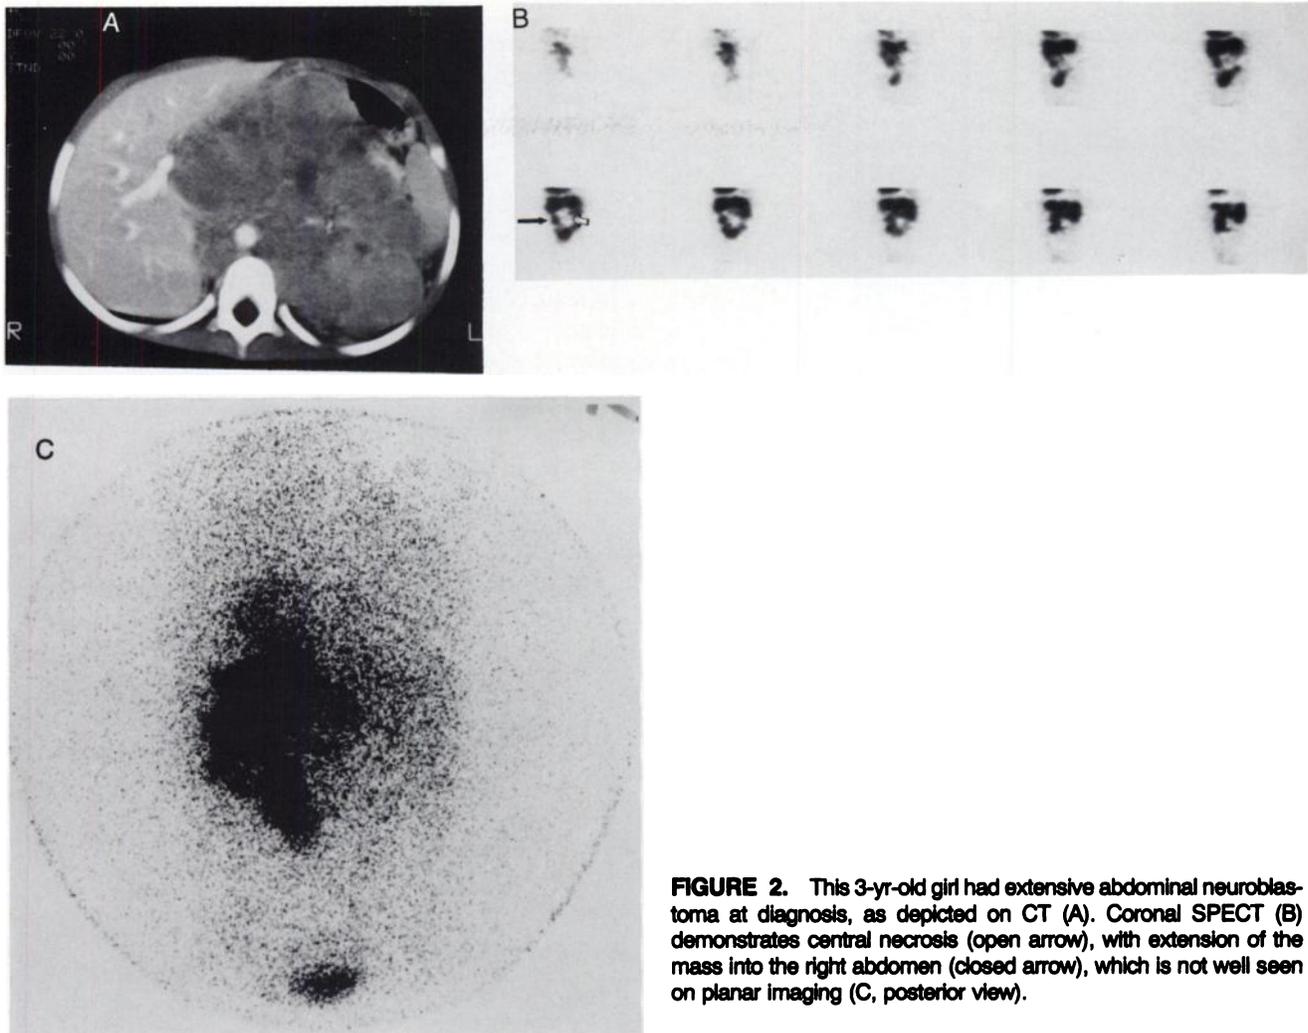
This 3-yr-old girl had extensive abdominal neuroblastoma at diagnosis, as depicted on CT (A). Coronal SPECT (B) demonstrates central necrosis (open arrow), with extension of the mass into the right abdomen (closed arrow), which is not well seen on planar imaging (C, posterior view).
